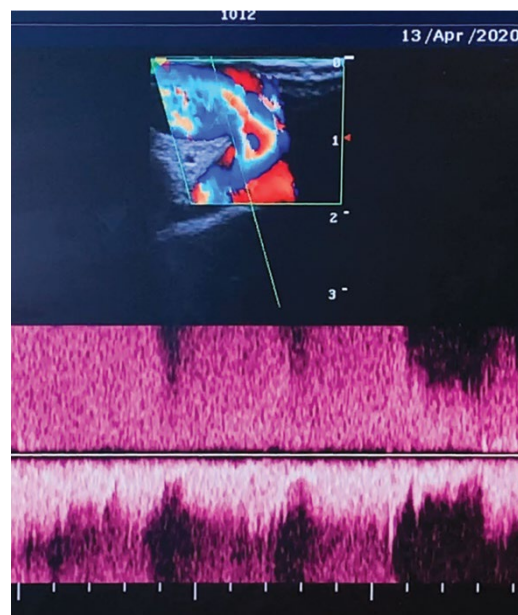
Patency of the splenorenal shunt confirmed by ultrasound Doppler data
